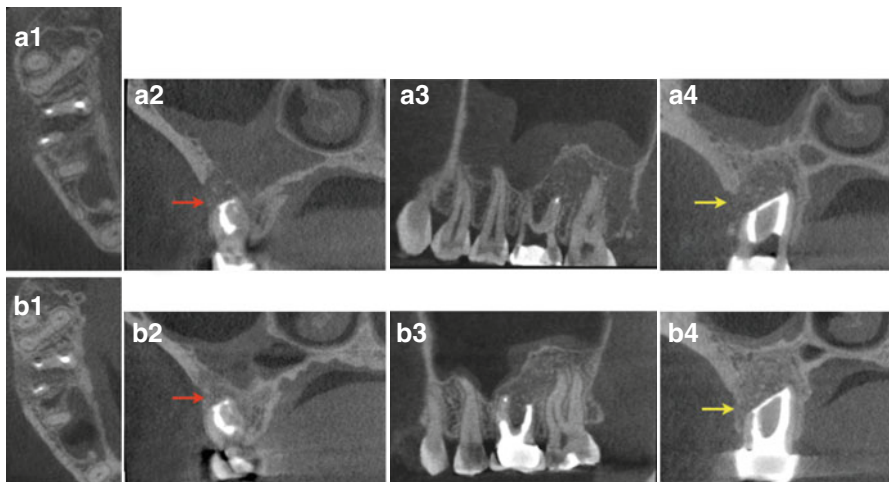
Continuation of case presented in Figs. 6.19 and 6.20: immediate postsurgical CBCT scan (a.1–a.4). Note buccal defect (*red and yellow arrows*). (b.1–b.4) 6-month recall CBCT scan (b.1–b.4). Note the initial regeneration of the defect including the buccal cortical plate. One-year recall CBCT scan demonstrating complete remodeling of the defect and the buccal plate (*red and yellow arrows*) (c.2–c.4)
